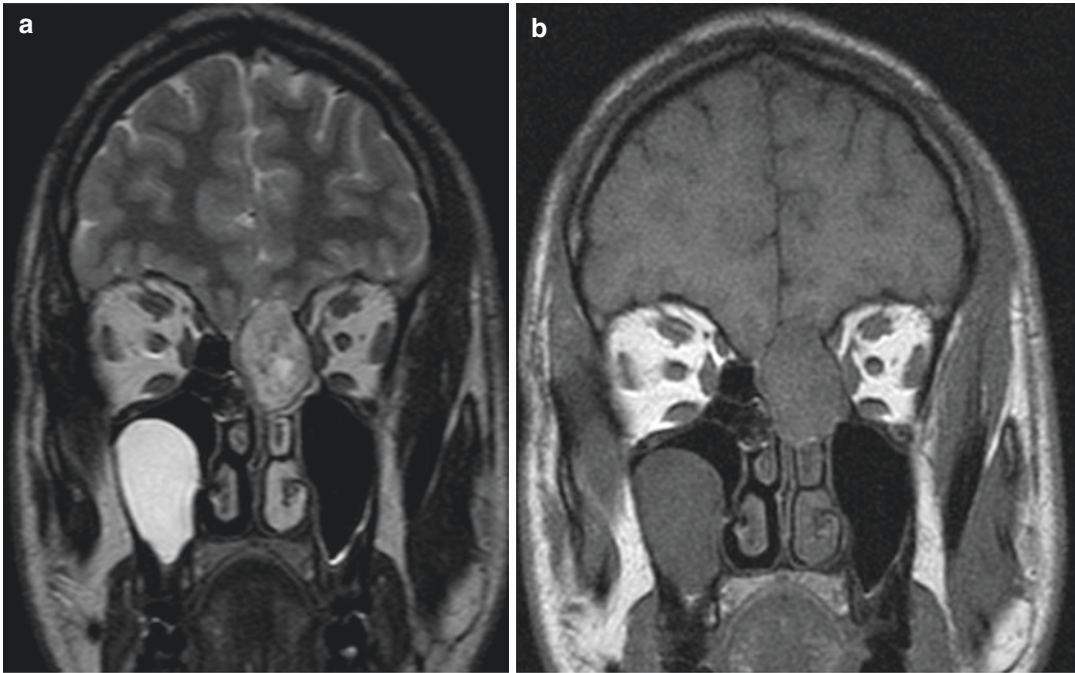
(a) Coronal T2-weighted MRI. Tumor mass in the left anterior ethmoidal cells with superior extension. Displacement of the brain without brain invasion. Retention cyst in the right maxillary sinus. (b) Coronal
